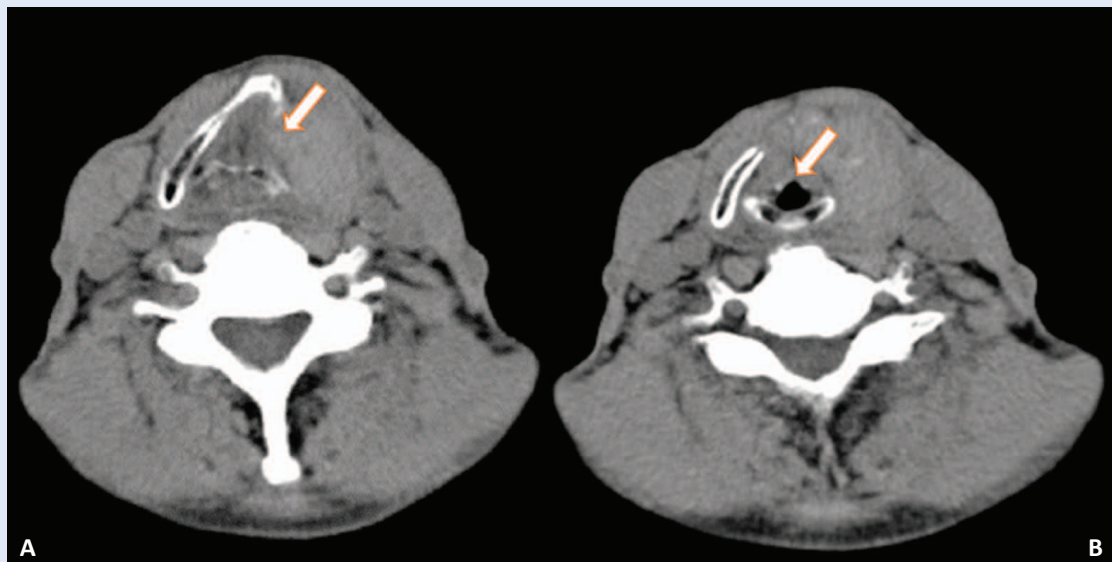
(A) Axial native computed tomography scan showing tumor mass infiltrating the thyroid cartilage (supraglottic level) causing “mass effect” on laryngeal structures (arrow) and asymmetry in vocal fold movement on flexible nasopharyngolaryngoscopy, but without vocal fold infiltration as it is shown on the glottic level (arrow) in image (B).
